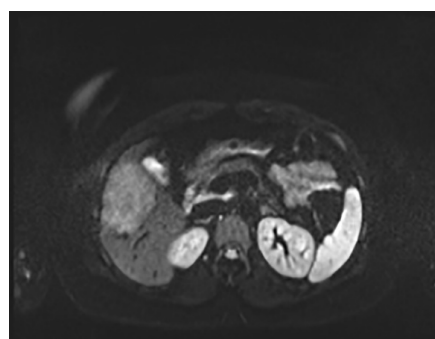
MRI (diffusion phase) showing a lesion in liver segment V.
